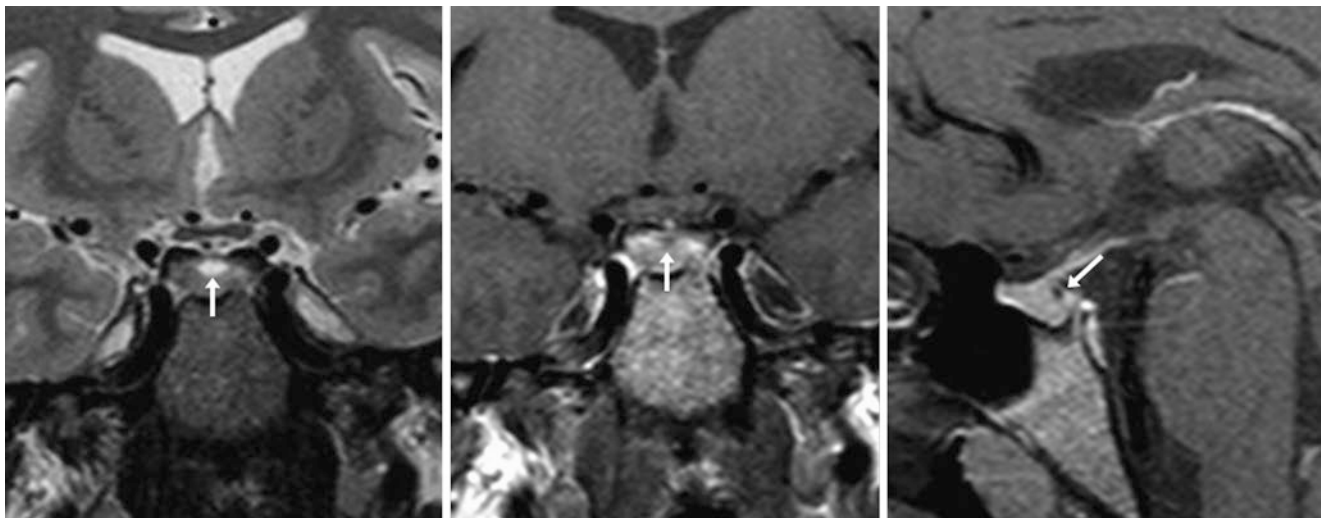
The patient was a 23-year-old female with prolactinemia. A 1.5 T MRI depicted a tiny 1.5- to 2-mm pars intermedia cyst (RCC) just posterior to the stalk along the superior surface of the gland (*arrows*) on coronal T2WI (*left*), on postcontrast coronal T1WI (*middle*), and on postcontrast sagittal T1WI (*right*). The symptoms were considered unrelated to the RCC
